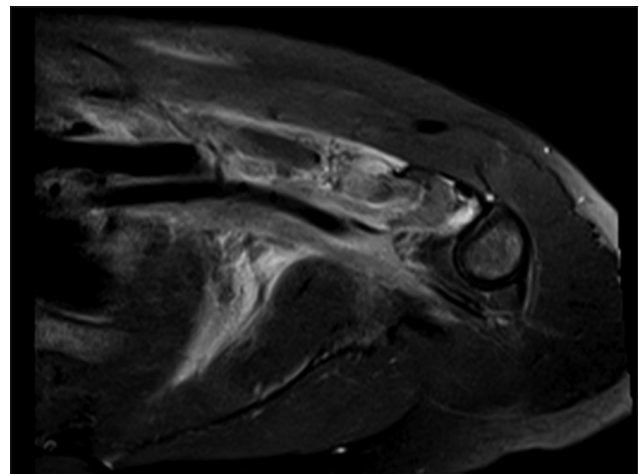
Magnetic resonance imaging - Sagittal image
